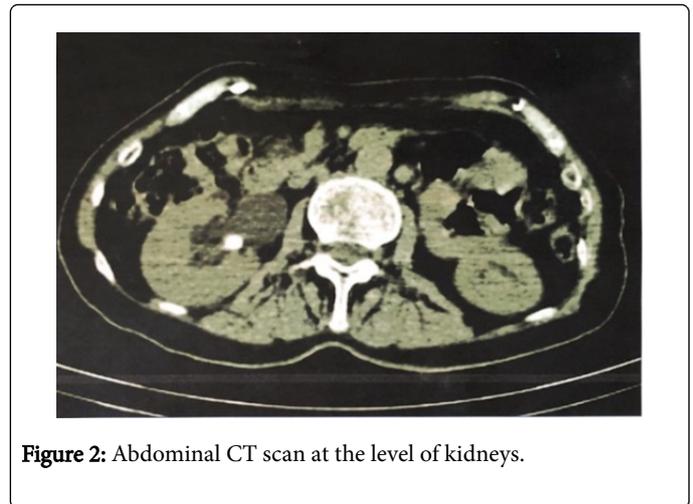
Abdominal CT scan at the level of kidneys.
